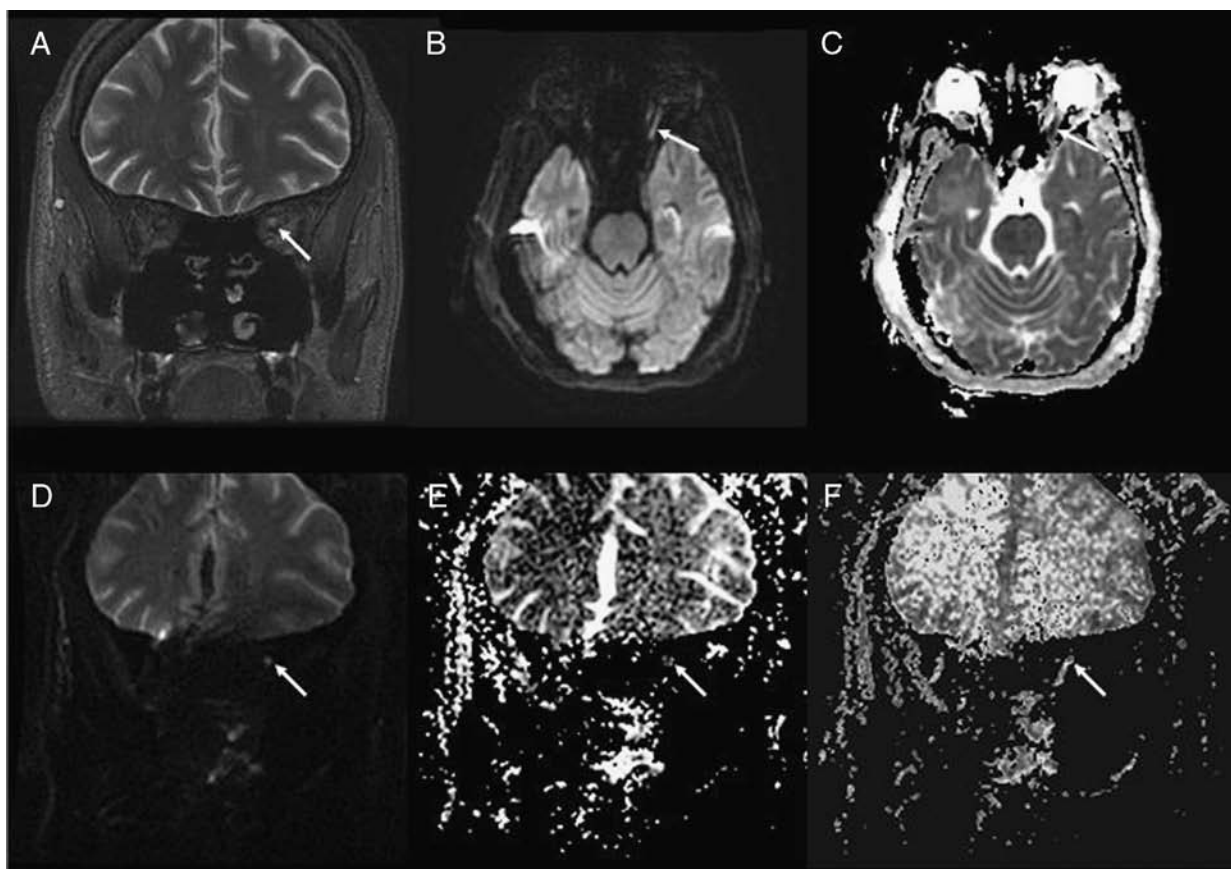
Magnetic resonance imaging without contrast of orbits: (A) coronal T2-weighted image, (B) axial diffusion-weighted imaging, and (C) apparent diffusion coefficient map show T2 prolongation and restricted diffusion along the orbital segment of the left optic nerve (arrows). This is confirmed on (D) coronal diffusion tensor imaging, (E) mean diffusion map, and (F) fractional anisotropy map with restricted diffusion and decreased fractional anisotropy consistent with acute-subacute ischemia along the orbital segment of the left optic nerve (arrows).
